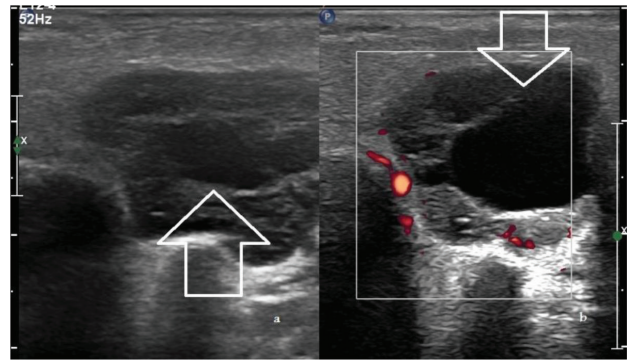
Ultrasonography (USG) of the left side of the face including parotid gland. (a) Long axis US image with high frequency linear probe (7 MHz) shows cystic lesion present in the tail region of superficial part of lobe (white halo arrow). (b) CFI shows no flow in the lesion (inverted halo arrow).
